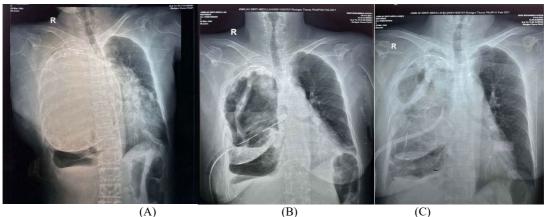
Chest X-ray before surgery (A), two days after surgery (B), and two weeks after surgery (C)
